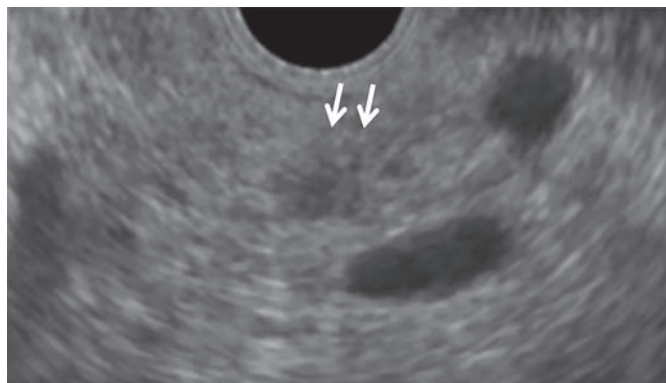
An ultrasonography image showing a pancreatic cyst in the body of the pancreas (arrows).
